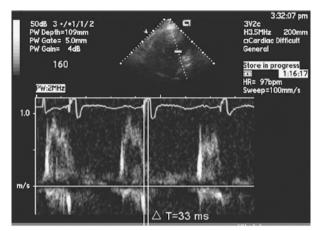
Doppler signals for mitral inflow method.
